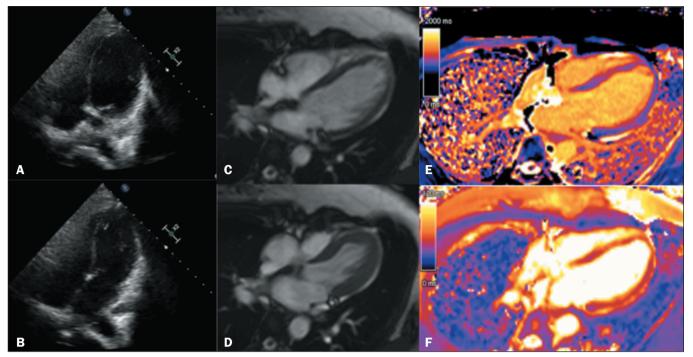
Echocardiogram and CMR of a 43-year-old female patient with chest pain after a seizure. The echocardiogram images (A,B) and the cine-SSFP CMR images (C,D), both in four-chamber views, demonstrate mid-ventricular segmental hypokinesia, particularly in septal segments. The T1 map (E) and T2 map (F) show diffuse edema, more pronounced in the hypokinetic segments.
